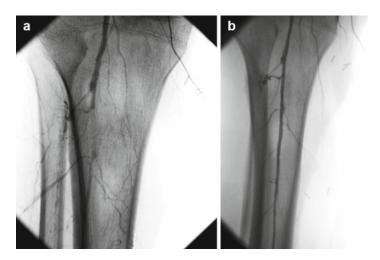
A 74-year-old man with right leg critical limb ischemia (<1/2 block claudication, a hallux blister, ABI of 0.33). A pre-operative angiogram showed a widely patent right common and external iliac arteries, an occluded SFA with reconstitution of the popliteal artery at the adductor canal via collaterals from the profunda femoris. Distally, however, the anterior tibial and tibioperoneal trunk arteries were occluded with distal reconstitution of the peroneal artery that fed the dorsalis pedis and posterior tibial arteries at foot. (a) Intraoperative angiogram after performing a right femoral to popliteal bypass. There is a chronic total occlusion of the anterior tibial artery and tibioperoneal trunk with distal reconstitution of the peroneal artery. (b) Successful crossing and angioplasty of the tibioperoneal trunk and peroneal artery with run-off to foot. Post-operatively, the patient's toe ulcer healed and his exercise tolerance increased to >8 blocks. (c) Surveillance ultrasound of the peroneal artery showing a PSV of 108 cm/s. Approximately 10 months after the initial intervention, the patient had a surveillance ultrasound and MRA that suggested a stenosis at the tibioperoneal trunk. (d) An angiogram confirmed a patent bypass graft and popliteal artery with two stenoses of the proximal peroneal artery (arrowheads). (e) Successful angioplasty of the stenoses (arrowheads)
